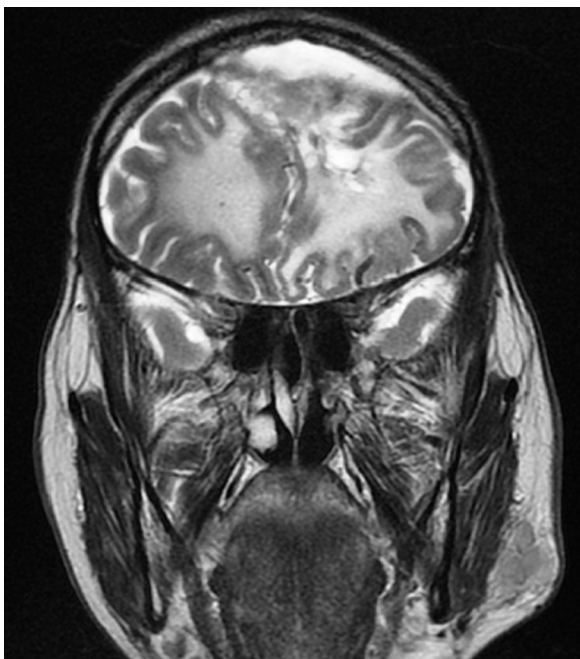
MRI Brain (T2w image) scan shows residual tumor.
